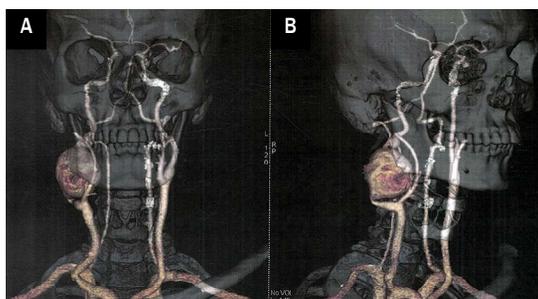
Reconstructed computed tomography carotid angiography showing massive extracranial carotid artery aneurysm
